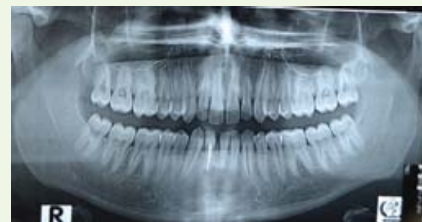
Follow up X-ray OPG after 6 months
